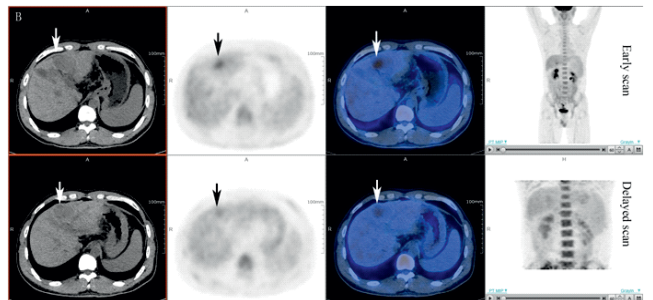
Male, 36 years old. There was a low-density nodule in left lobe. Early scan SUVmax: 3.6, delayed scan SUVmax: 2.1, RI-SUVmax:-40.0%. Pathological diagnosis: HCC, grade II.
